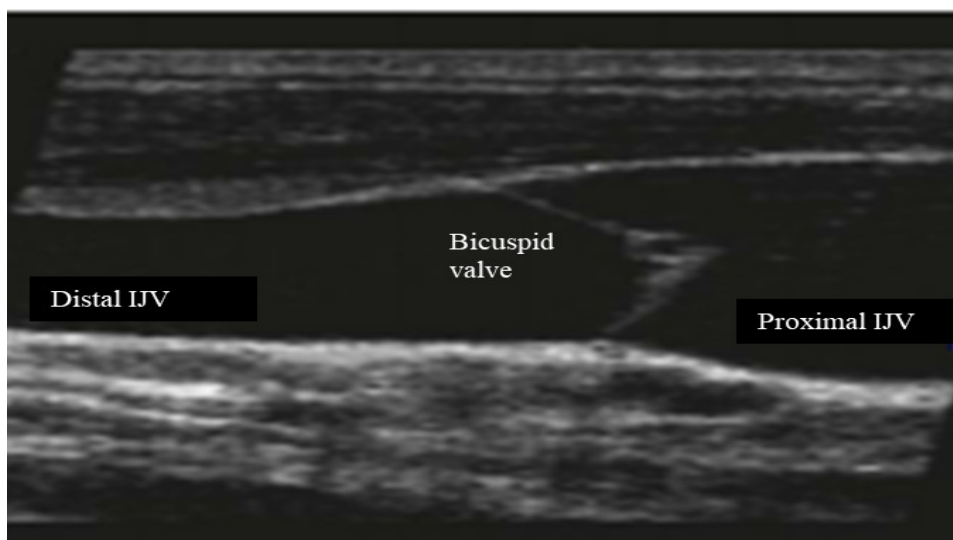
Longitudinal Ultrasound view of internal jugular vein, (IJV) valve is located about 0.5 cm above the union of the subclavian vein and the IJV at the lower limit of the jugular bulb.
